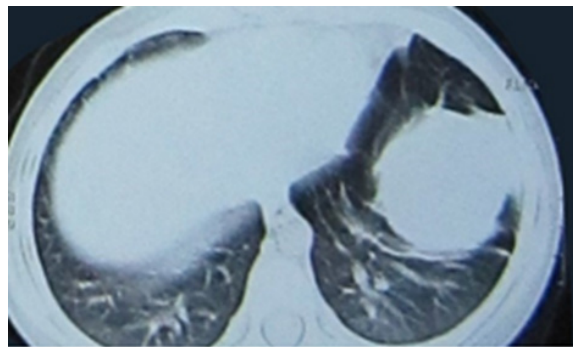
Chest CT scan indicative of hydatid cyst.
